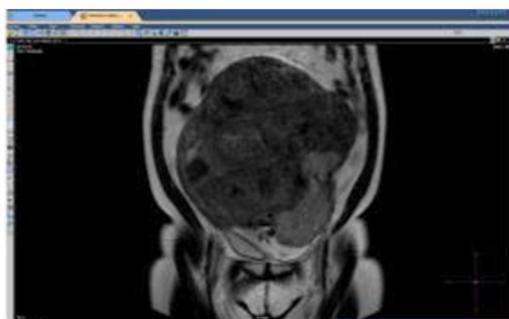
Magnetic Resonance Imaging (MRI) of abdomen and pelvis.
